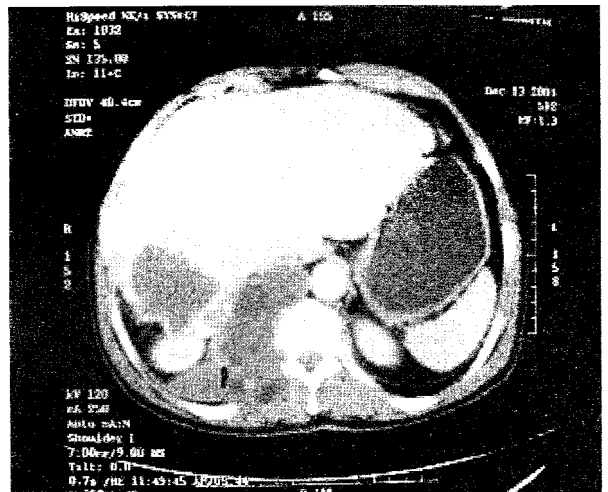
CT scan of the abdomen showing calcified hepatic pericyst in the right lobe, hepatic hydatid cyst of the left lobe, and hydatid of the spine.
